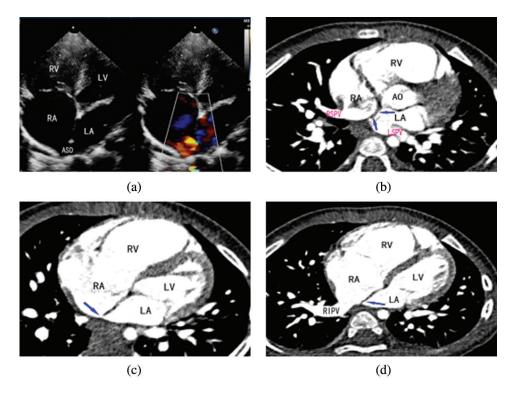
Right pulmonary veins connecting to RA and posterior ASD in an 8-year-old boy. (a) Apical four chamber view showed a posterior ASD. (b) CT section at the level of right superior pulmonary vein and left superior pulmonary vein. Right superior pulmonary vein connected to RA. Atrial septum was intact at this level. (c) Cross-sectional image beneath right superior pulmonary vein level. There was a posterior ASD above right inferior pulmonary vein. (d) CT at right inferior pulmonary vein level. Atrial septum was also intact in this section. It was obvious that this type of ASD was neither adjacent to superior vena cava nor to inferior vena cava (RA, right atrium; ASD, atrial septal defect)
